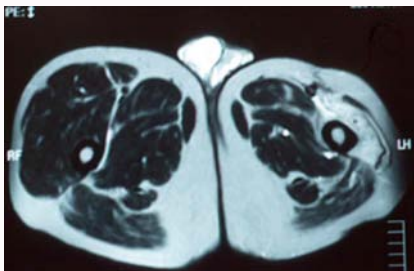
CT shows previous resection of vastus lateral is muscle and tumor invasion around the femoral vessels and femur.
